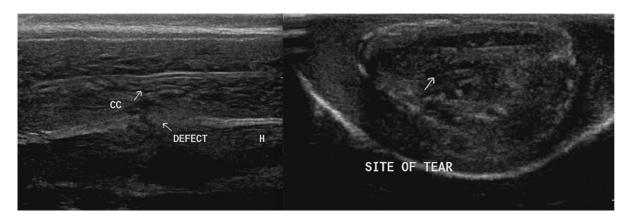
Ultrasound Finding of Penile Fracture. Adapted from Chahal *et al.* [19]. Copyright BMJ Publishing Group. Reprinted with permission. Ultrasound images showing ventral haematoma (H) and defect in the wall of the right corpus cavernosa (CC).
